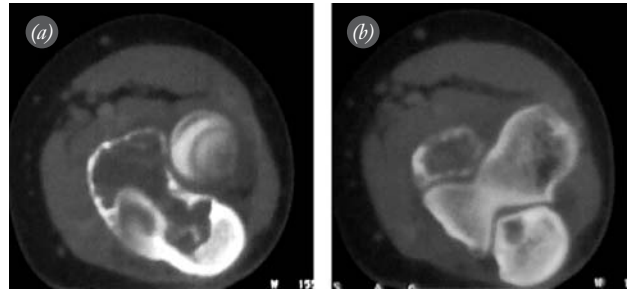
(a, b) CT views showing the expansile, osteolytic lesion located at the anterior aspect of the proximal ulna.
